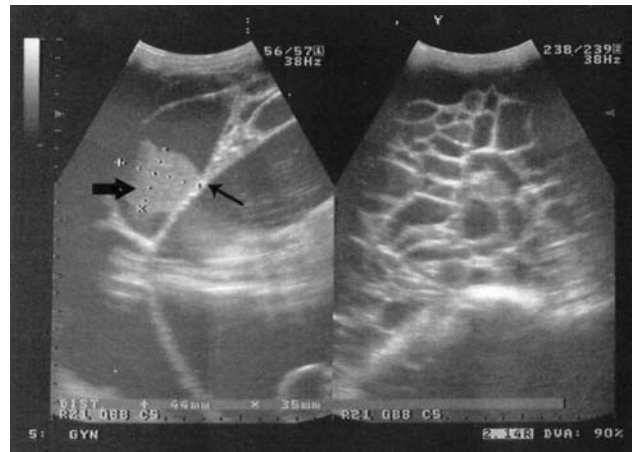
Ultrasounds scan showing a large cystic multilocular mass containing multiple thick septations (small arrow) and a solid component (big arrow).
